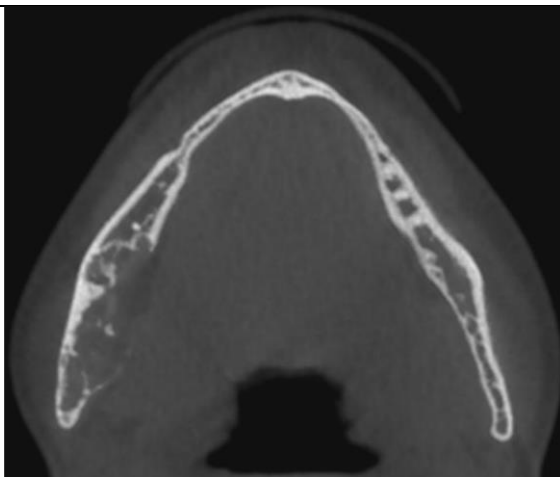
Axial cone-beam computed tomographic image shows expansion and thinning of the adjacent cortical plates. There is perforation of the lingual cortex without evidence of periosteal reaction
